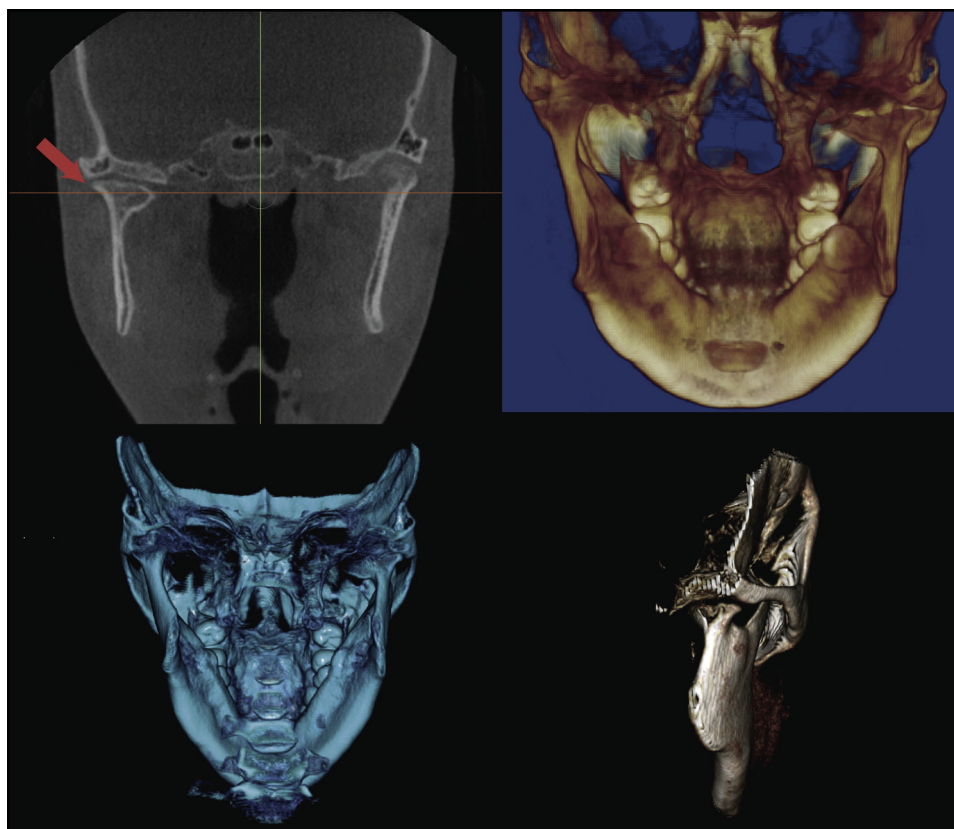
Thirty-month posttreatment CBCT scan showing remodeling of the fractured mandibular right condyle.
